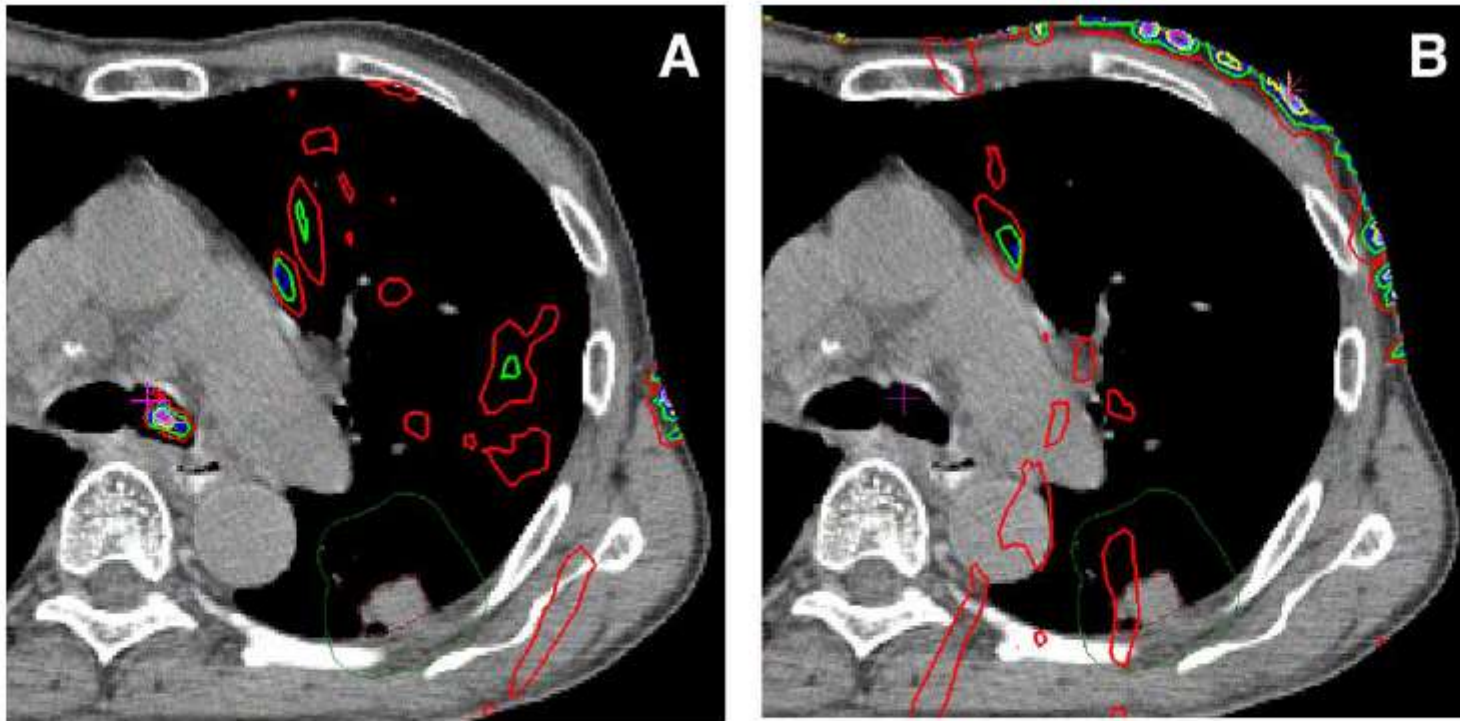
Relative isolevels of the differences between dose distributions calculated with the same treatment plan for breathing phases close to inhale and close to exhale. Plotted are the positive differences for the dose subtractions of breathing phases close to inhale and exhale, (A) inhale-exhale and (B) exhale-inhale. The differences are normalized to the doses calculated based on the CT-data set close to inhale: red 1%, green 2%, dark blue 3%, yellow 4%, light blue 5%, and magenta 6%. The CT data sets were acquired under the current 4DCT protocol at Massachusetts General Hospital.
